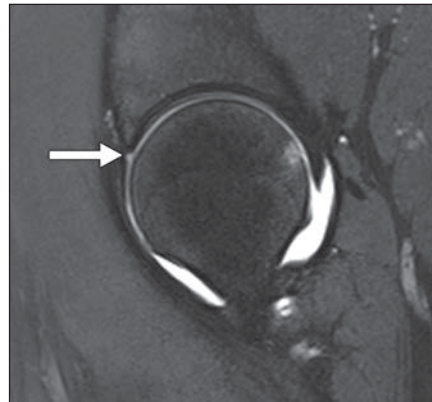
17-year-old boy with transverse ligament–labral junction sulcus. Coronal fat-saturated intermediate-weighted MR image shows transverse ligament–labral junction sulcus (*arrow*), which forms when transverse ligament intersects with acetabular labrum.
